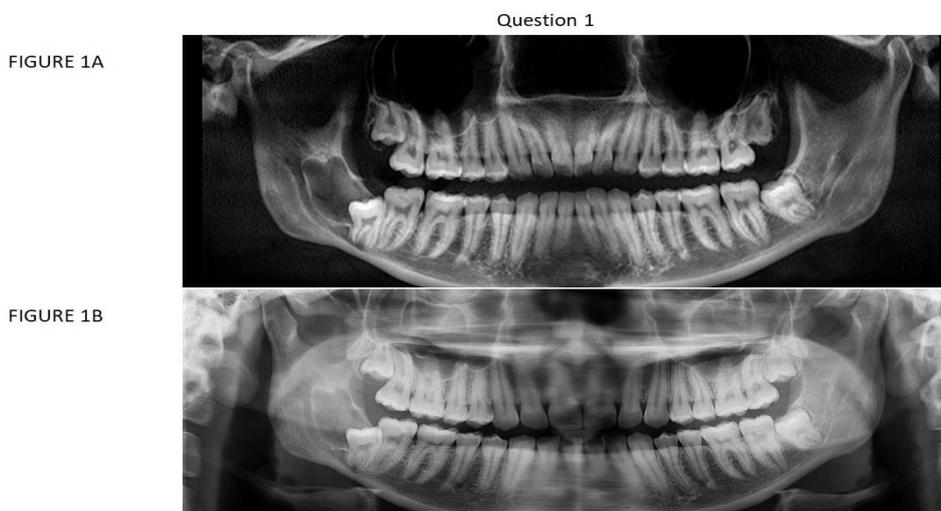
&1B: Cone Beam Computed Tomography (CBCT) and panoramic images of the same patient used in question 1.
